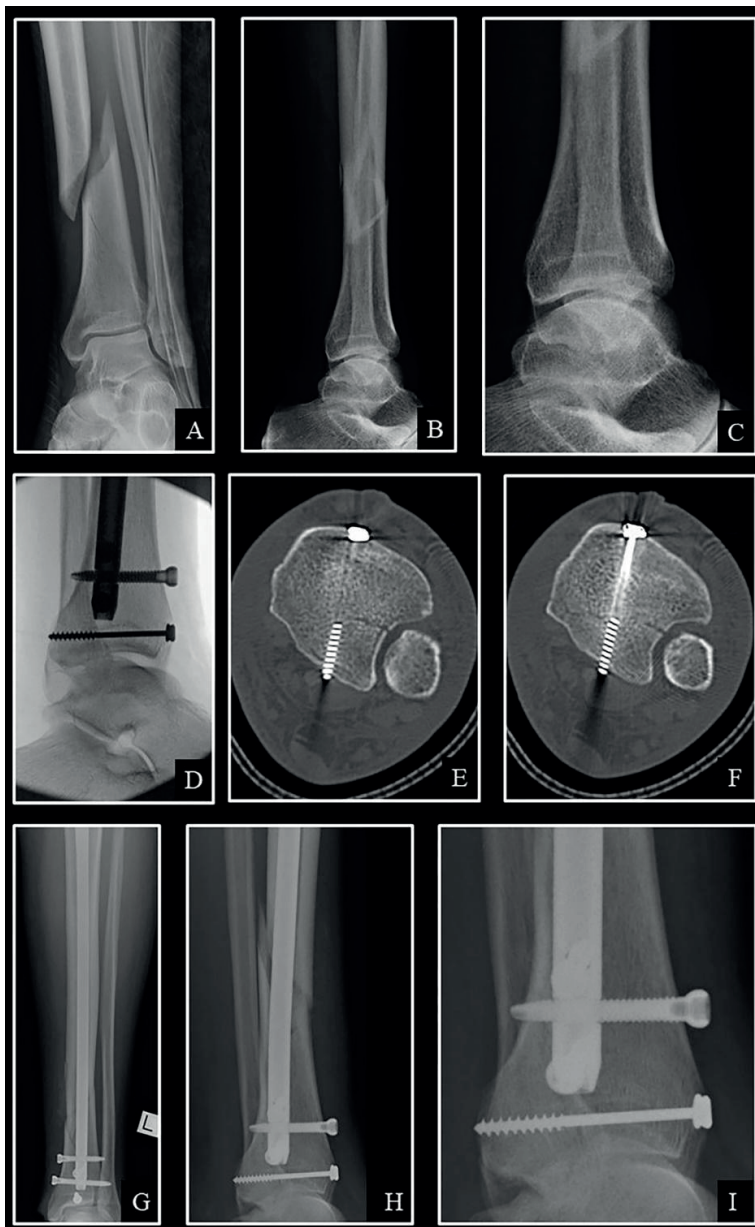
Example of reduction with “malleolus-first” fixation of an occult PMF: A 51-year-old man sustained a low-energy trauma resulting in a distal third spiral TSF (A–C). “Malleolus-first” fixation was applied with one AP partially threaded cancellous lag screw (D). Postoperative CT scans confirm maintained reduction (E and F), and 2-week plain radiographs show adequate fixation of the posterior malleolar fragment (G–I).
